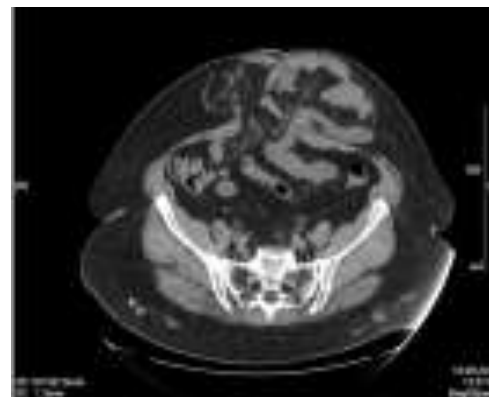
Anterior abdominal wall view and computed tomography hernioabdominometry of patient C., 62 years old with postoperative ventral hernia (M2W3R0) and adhesions with chronic intestinal obstruction
